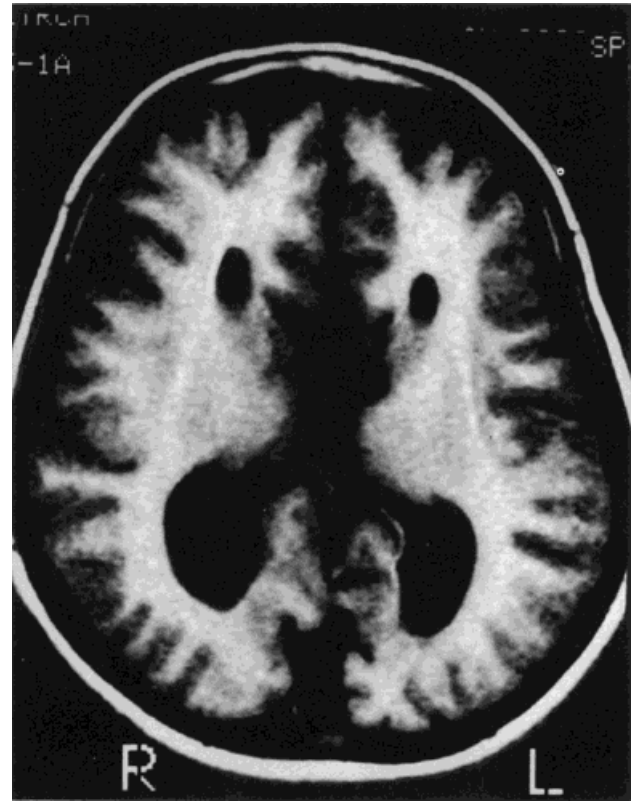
Cranial MRI scan of the mother.
